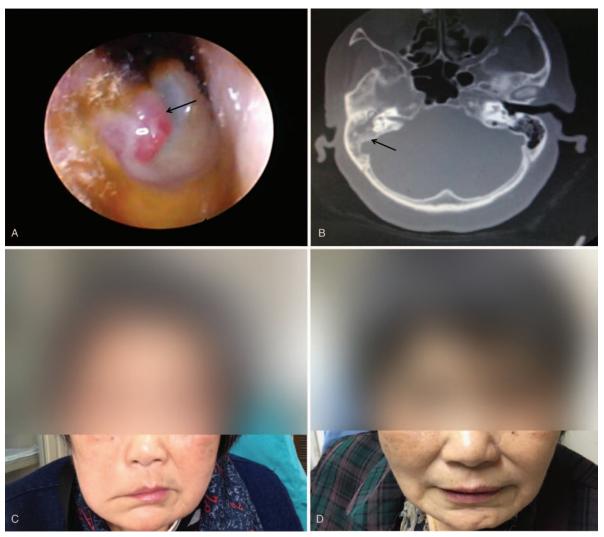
(A) Otoscopy examination showing abundant purulent secretions deep in the right external auditory canal, and granulation proliferation in the posterior part of membranae tensa. (B) Computed tomography scanning showing the tumor presenting in the tympanic and mastoid segments of right ear. (C) The patient had facial nerve paralysis of House-Brackmann Grade VI. (D) Facial nerve function improved to House-Brackmann Grade III at 30 months after surgery.
